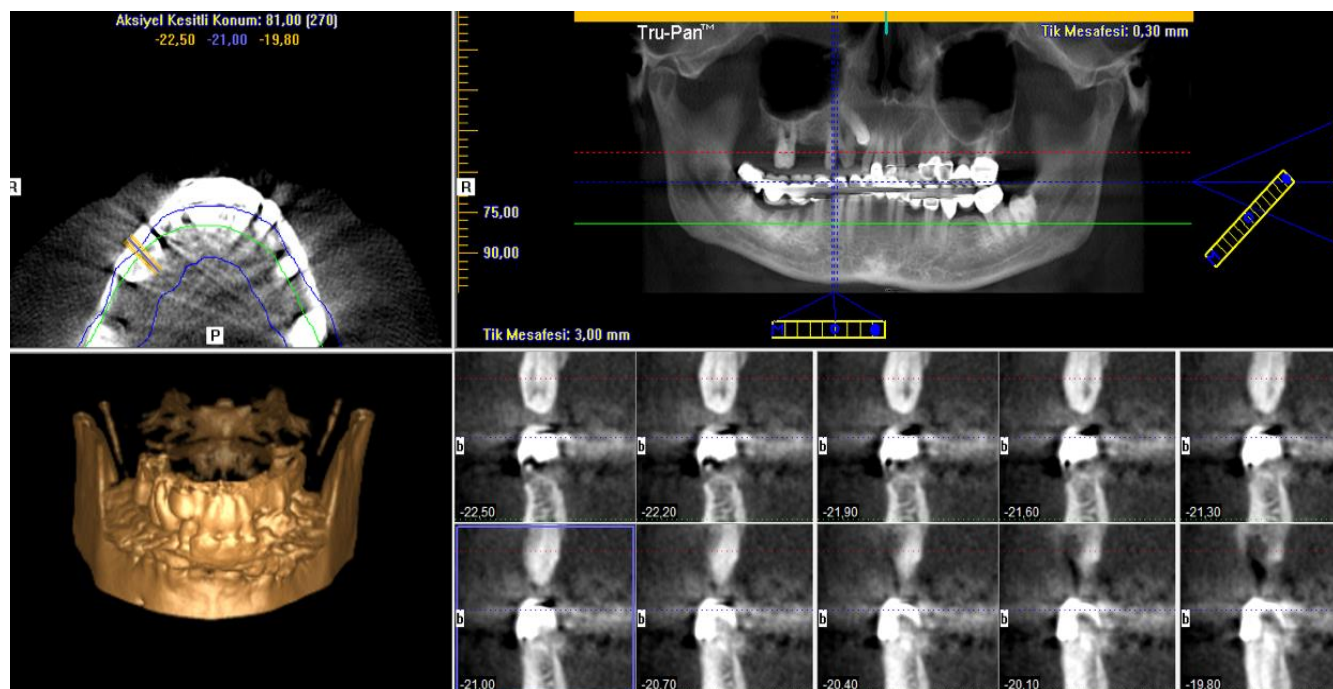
Metal artifact from metal restorations most commonly observed on CBCT image
